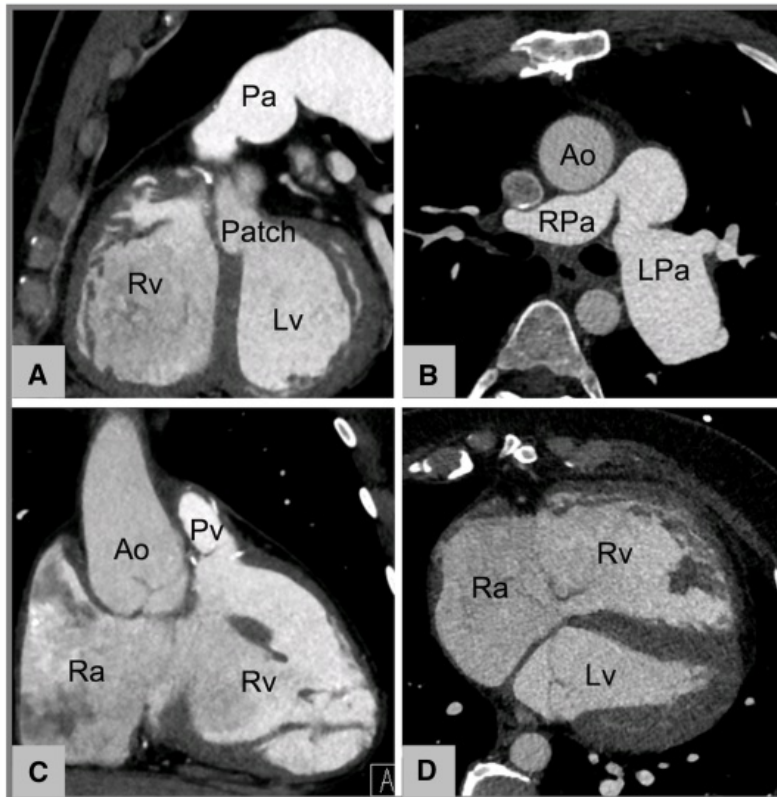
Cardiac CT for the postoperative follow-up of congenital heart disease. (A–D) Thirty-one-year-old male with repaired Tetralogy of Fallot, postsurgical LPa aneurism and Rv dilatation. Ventricular septal defect has been repaired by using a patch (A). Images by courtesy of Francesco Bianco, Ospedale Riuniti Ancona, Ancona (Italy). Ao, aorta; CT, computed tomography; LPa, left pulmonary artery; Lv, left ventricle; Pa, pulmonary artery; Pv, pulmonary vein; Ra, right atrium; RC, right coronary artery; Rpa, right pulmonary artery; Rv, right ventricle.
